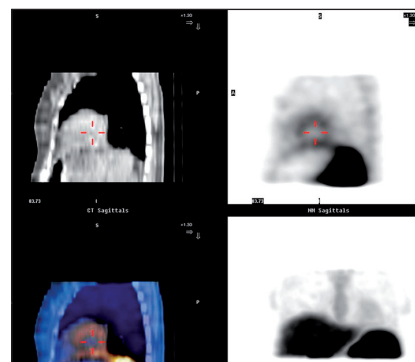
Images of case 2. Sagittal CT, SPET, fused and MIP images demonstrating myocardium with increased depreotide uptake (myocardium/rib ratio =1.9).
